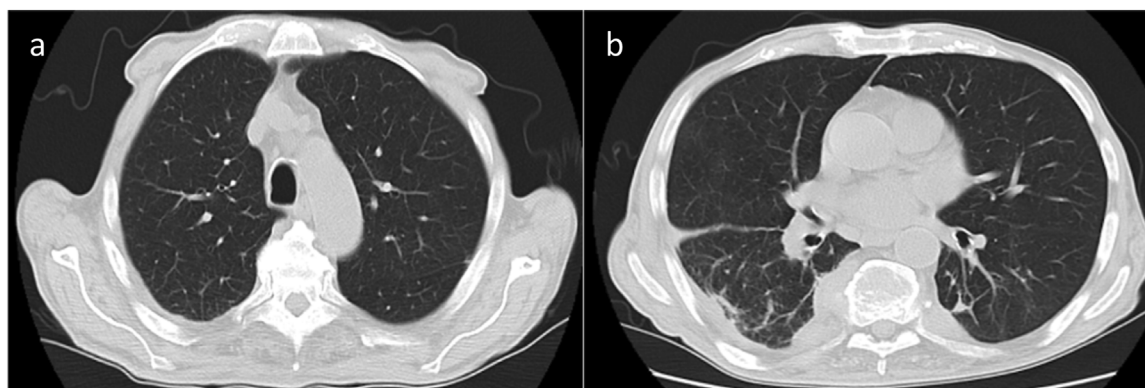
Chest CT axial images (a, b) lung window after treatment.
